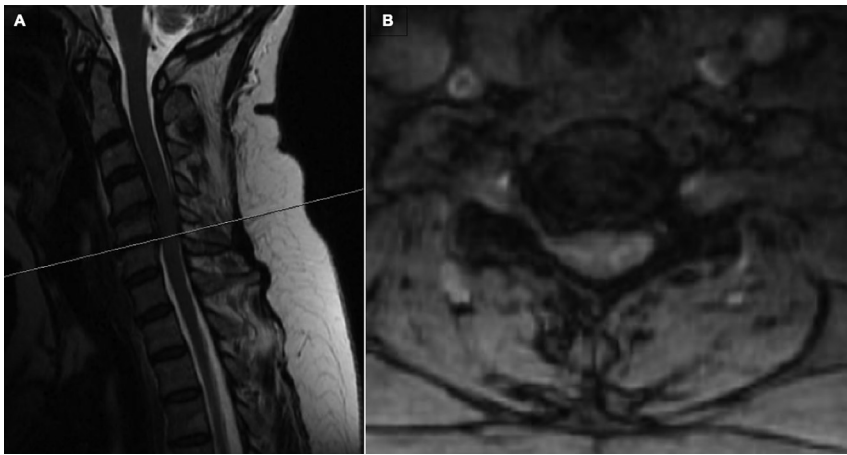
Panel A shows a T2-weighted sagittal image and Panel B shows a T2-weighted axial image of the cervical spine demonstrating a compression deformity of the C5 vertebral body and moderate spinal canal stenosis.
